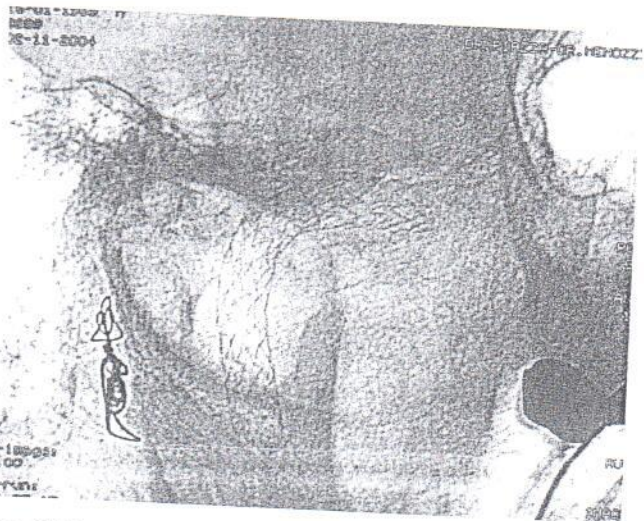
postinterventional X-ray allows for confirmation of the correct position of the stent into the carotid artery.
